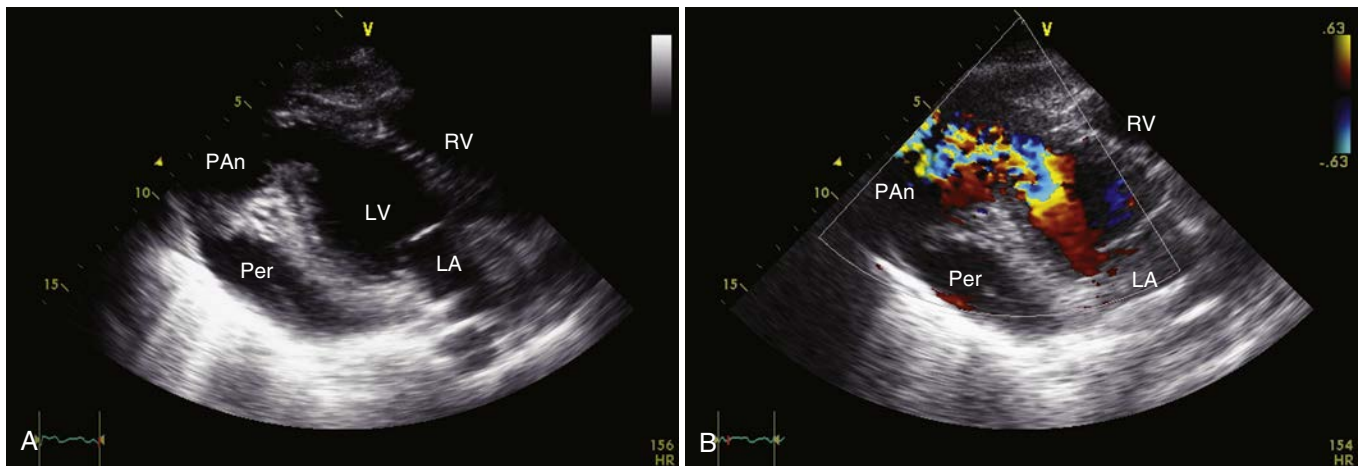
Free-wall rupture and left ventricular pseudoaneurysm. (A) Apical long-axis view, slightly off-axis, showing abrupt discontinuity of the inferolateral wall resulting in a communication between the left ventricle (LV) and a large cavity that appears to be a pseudoaneurysm. The cavity was pulsatile during real-time imaging (see Videos 31-20 and 31-21). (B) Using color flow Doppler, flow is seen from the LV toward the pericardial cavity (arrow). LA, Left atrium; PAn, pseudoaneurysm; Per, pericardial effusion; RV, right ventricle.
